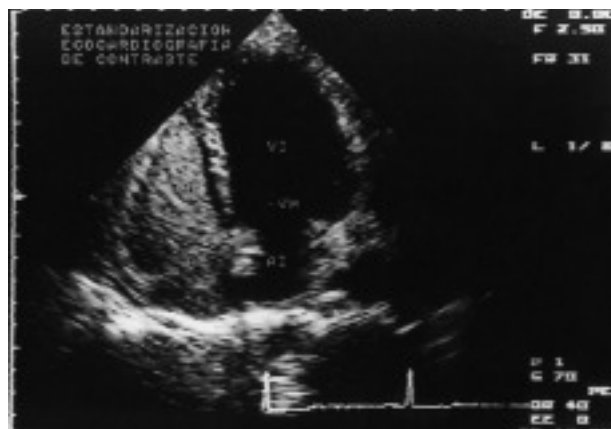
Note the evident delineation of the right ventricle in the 4-chamber apical projection with contrast echocardiography, which facilitates the measurement of its area in the different phases of the cardiac cycle. LA indicates left atrium; LV, left ventricle; MV, mitral valve.
